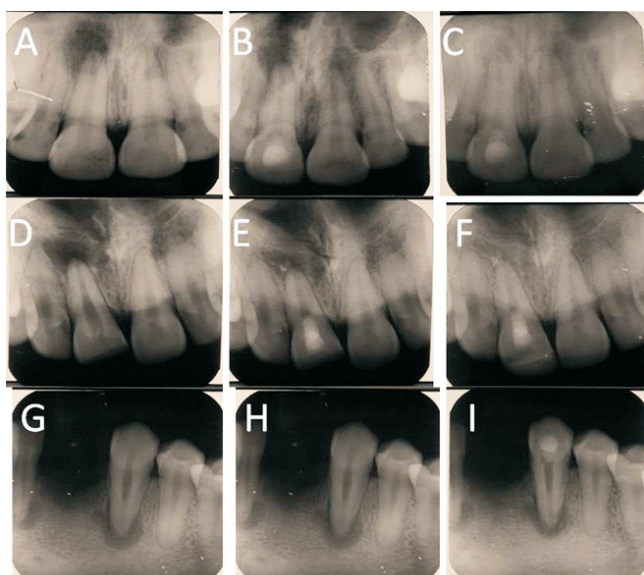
(A) A maxillary central incisor (#8) with periapical radiolucency in an 23-year old man. (B) The 6-month follow-up period reveal a significant decrease in periapical radiolucency after REPs. (C) The 24-month follow-up period revealed complete resolution of periapical radiolucency. Furthermore, the tooth responded to sensibility tests (EPT and cold) at the conclusion of 12-month follow-up period. (D) A maxillary central incisor (#8) with periapical radiolucency in an 19-year old man. (E) The 6-month follow-up periods reveal a significant decrease in periapical
